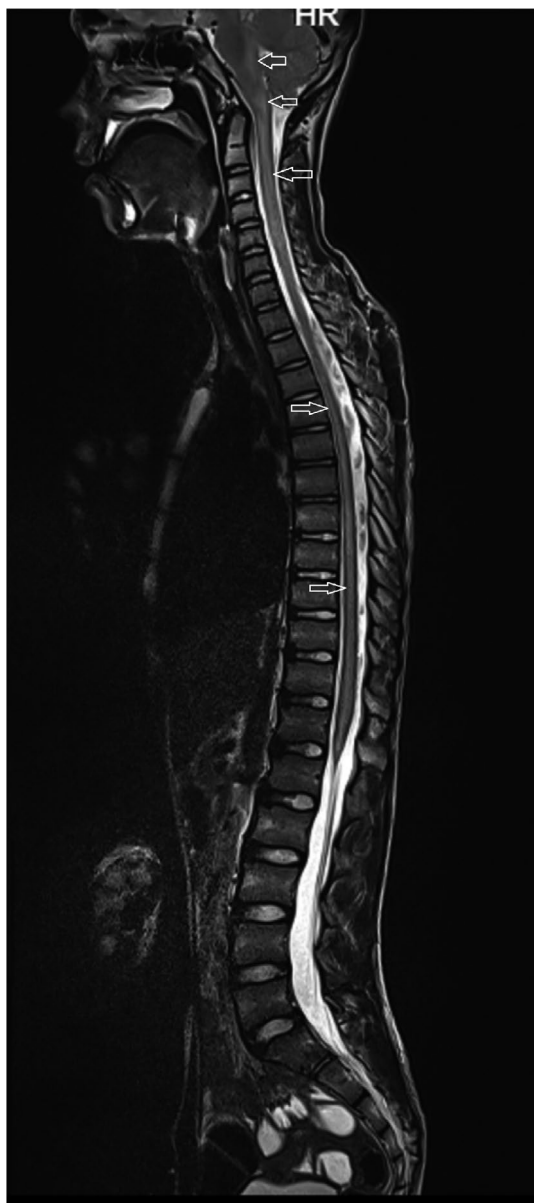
Sagittal T2 MRI image of the patient showing hyperintensity extending from the whole of the posterior brainstem to the central gray matter of the entire spinal cord (white arrows)
